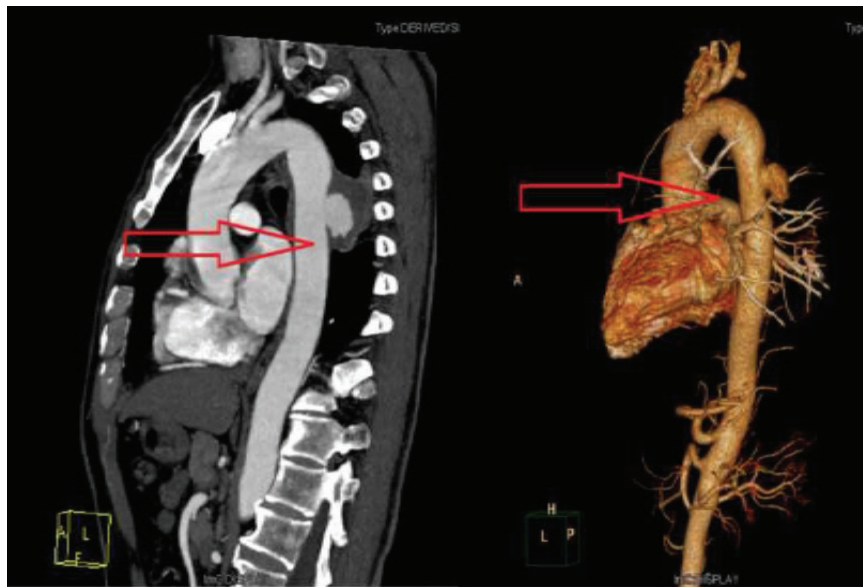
Aorta pseudoaneurysm and hematoma appear clearly on compute tomography angiography (CTA). Red arrow in this figure indicates the pseudoaneurysm and hematoma.
